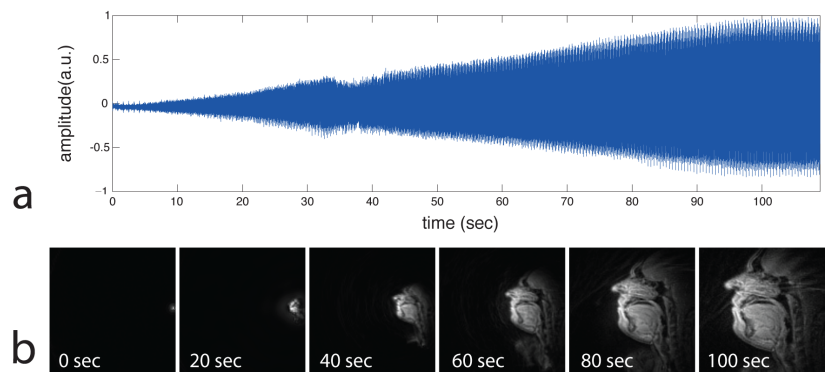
(a) Audio recording and (b) image frames at every 20 seconds during gradual ramp-up of gradients in a real-time MRI scan. Note that the gradient ramp-up increases acoustic noise and spatial resolution.
